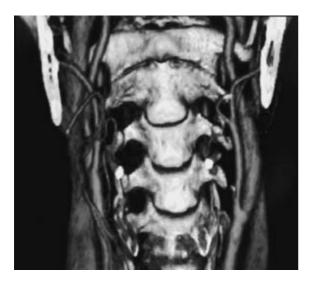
Three-dimmensional CT angiography after carotid endarterectomy shows a widely patent ICA and decreased stenosis.
